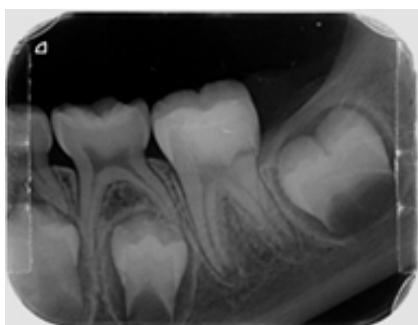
Immediate postoperative periapical radiograph of 3.6.*
